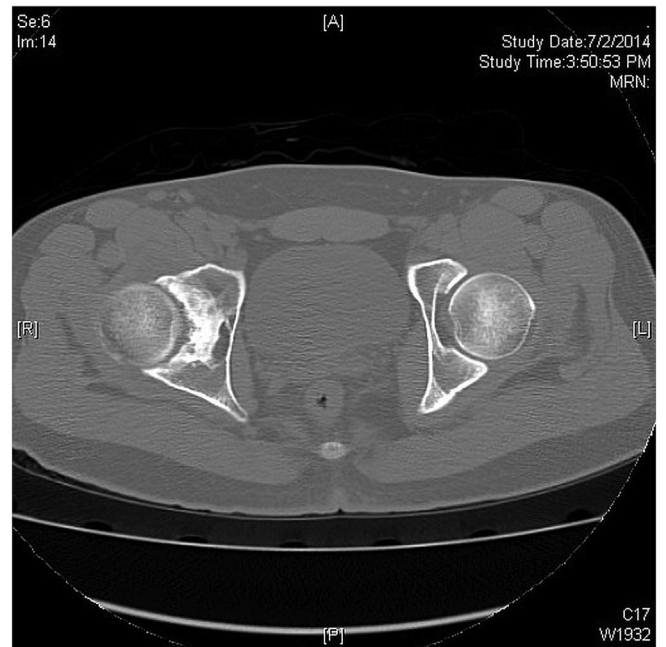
CT scan with further axial sections showing origin of the lesion from the base of the acetabulum.
